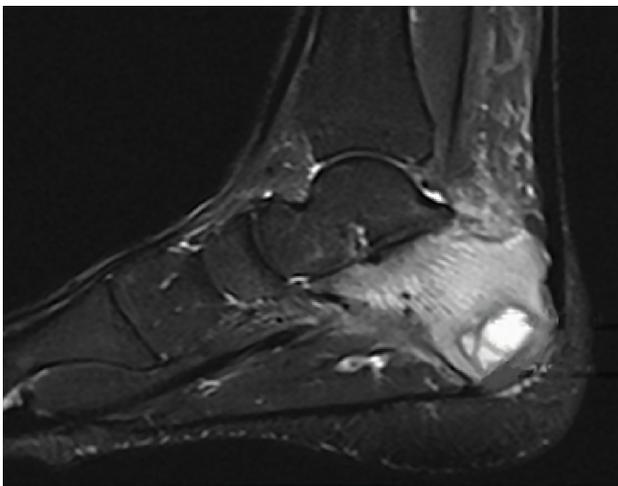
In sagittal T2-Weighted Fat-Suppressed MRI, a hyperintense abscess with an edematous area in the calcaneus.
